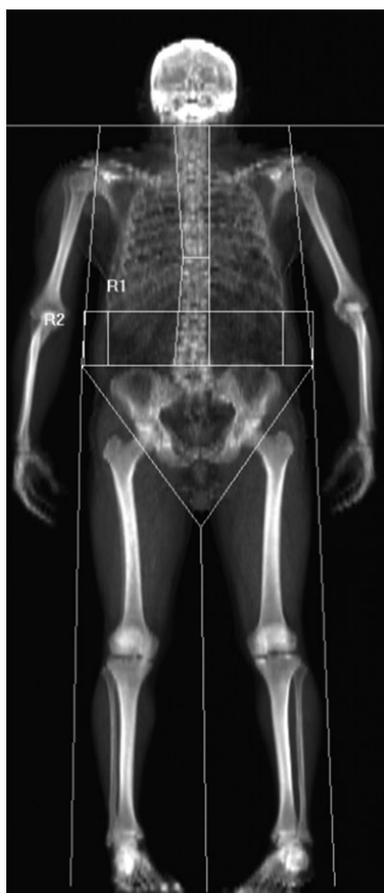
Image of a dual energy X-ray absorptiometry scan showing the abdominal region of interest (R2), defined as the area within the upper edge of the second lumbar vertebra, and the lower edge of the fourth lumbar vertebra and central abdominal region of interest (R1), defined as R2 but the vertical sides limited to the continuation of the lateral sides of the ribs cage.
